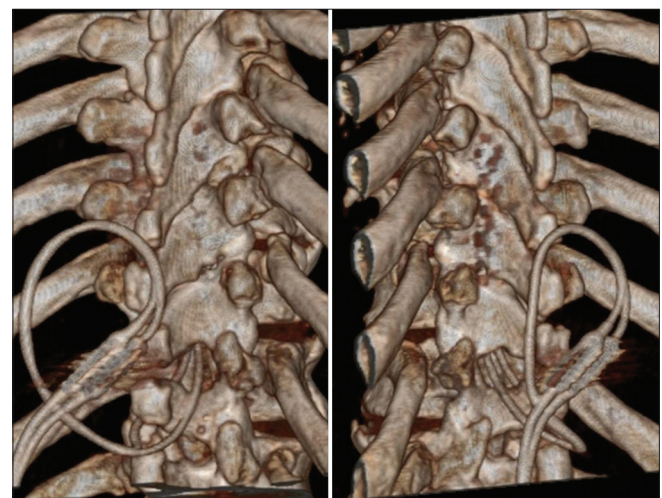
3-D postoperative CT scan of the same case described in Figure 3. The two cables of the lead paddle coming out from the spinal canal on both sides of the spinous process are shown
